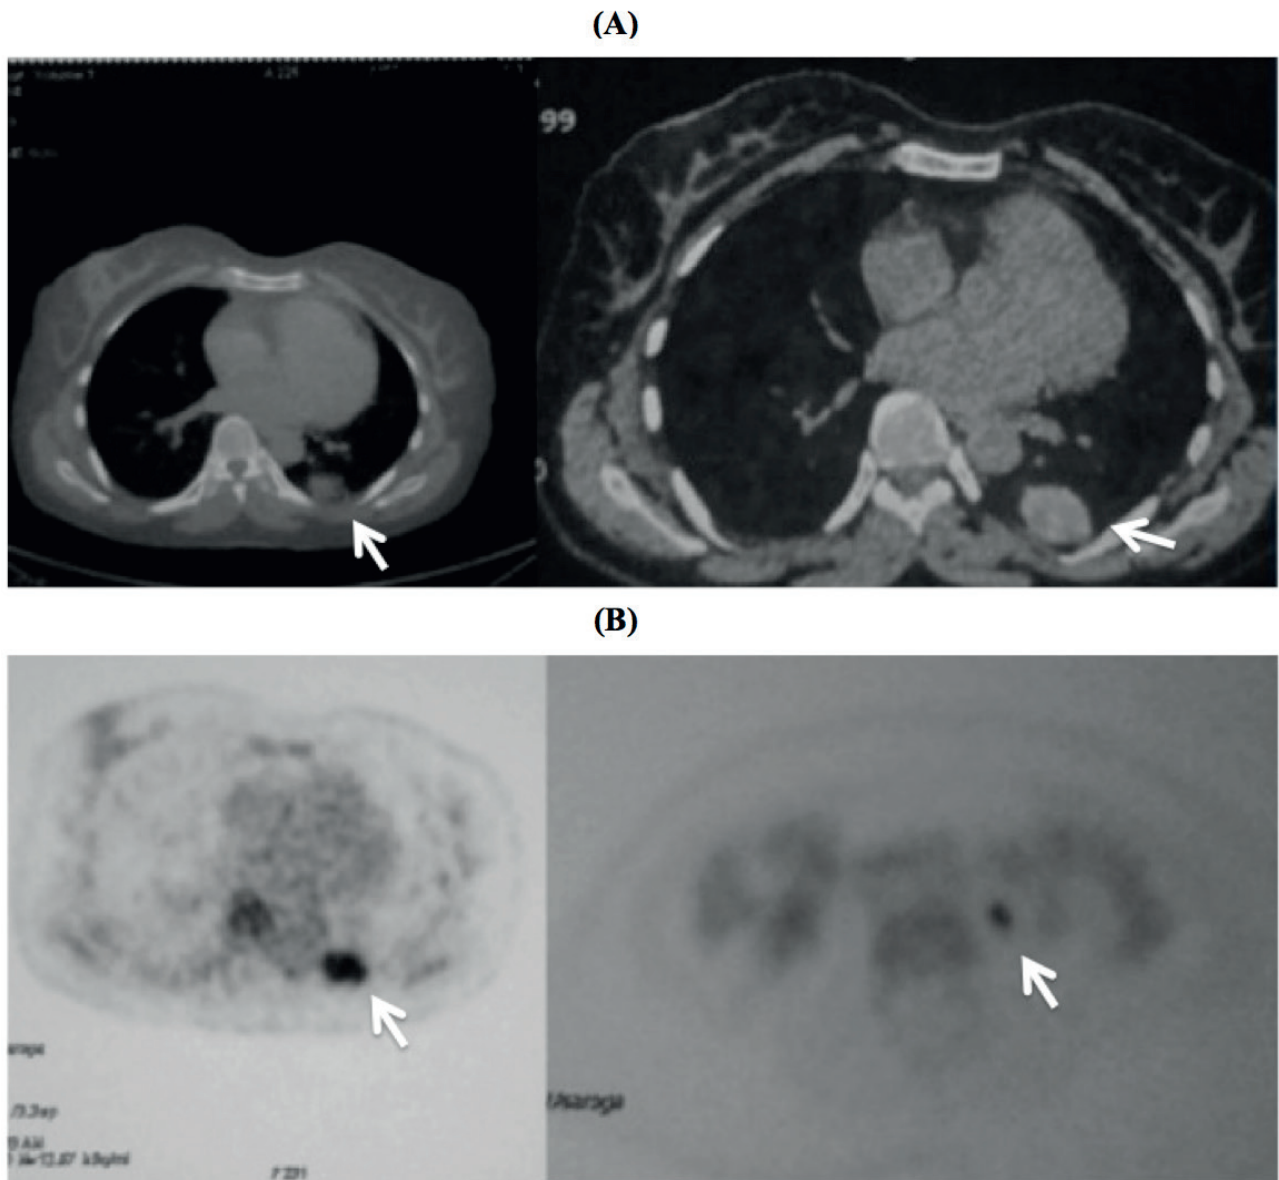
CT (A) and PET (B) scans. PET scan shows SUV max 5.7, suggestive of malignancy. The final diagnosis was aspergilloma (arrows).
